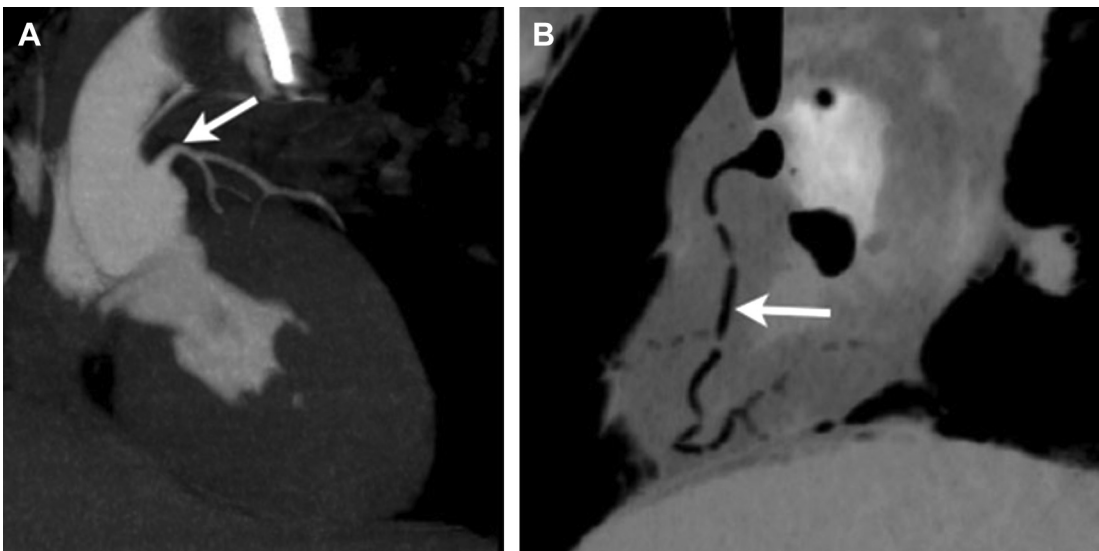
Postmortem CT angiography showing a normal left coronary artery (arrow) opacified by contrast (A) and right coronary artery (arrow) filled with air (B). (From Saunders SL, Morgan B, Raj V, Ruty GN. Post-mortem computerized tomography angiography: past, present and future. *Forensic Sci Med Pathol* 2011;7:276; with permission.)
